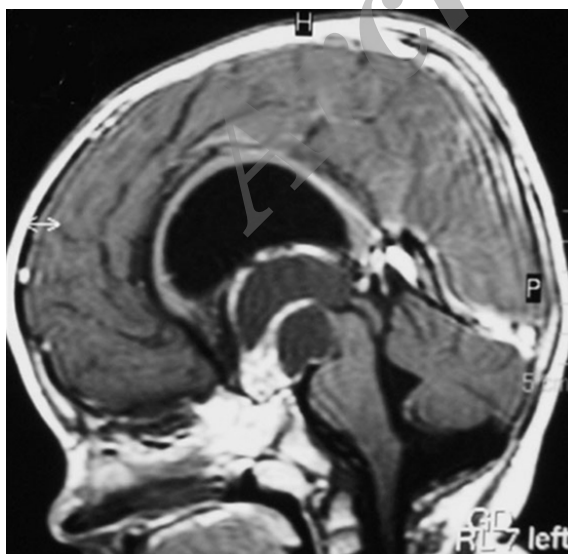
Preoperative, sagittal post-gadolinium injection MRI: The scan shows superior extension of the tumor with brainstem compression and displacement of the 3rd ventricle's floor.
